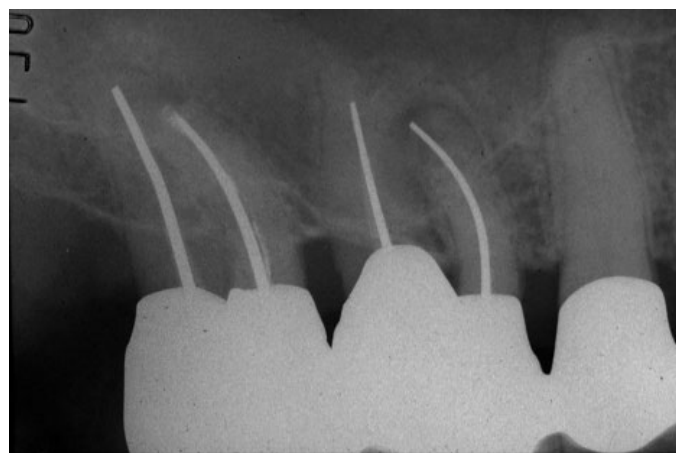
(B) Three years after distobuccal root resections and new castings. Periapical lesions developed around the mesiobuccal roots. During the extended treatment phase, the coronal ends of the silver points were periodically exposed to saliva.
